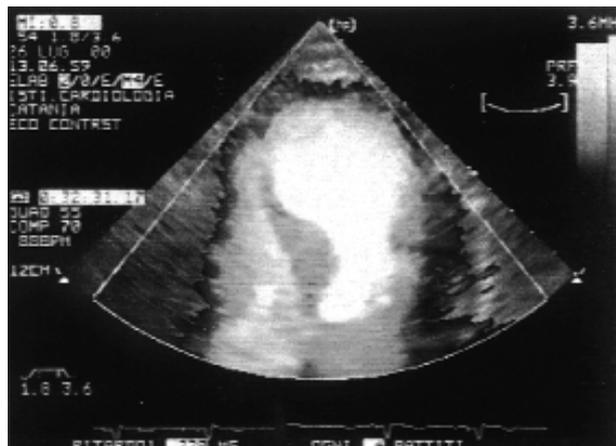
Myocardial contrast echocardiography demonstrated a normal septal perfusion in a patient with left bundle branch block and normal coronary arteries.
